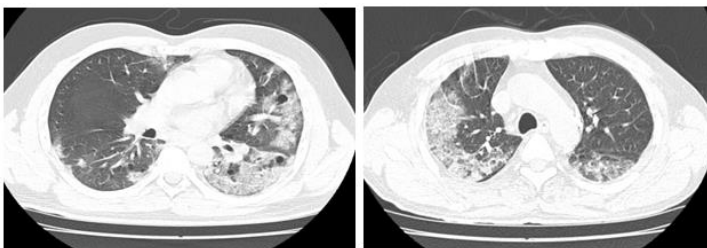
Axial HRCT image of 44yrs old male patient showing subpleural distribution of ground glass opacities in the right lung.
